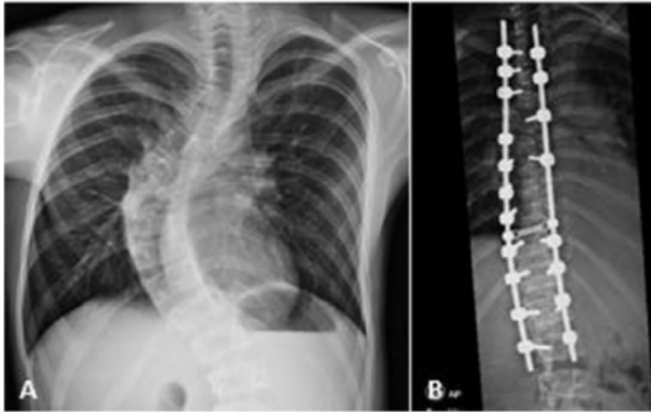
A) Chest X-ray: Scoliosis with right convexity. B) Postoperative Chest X ray.
